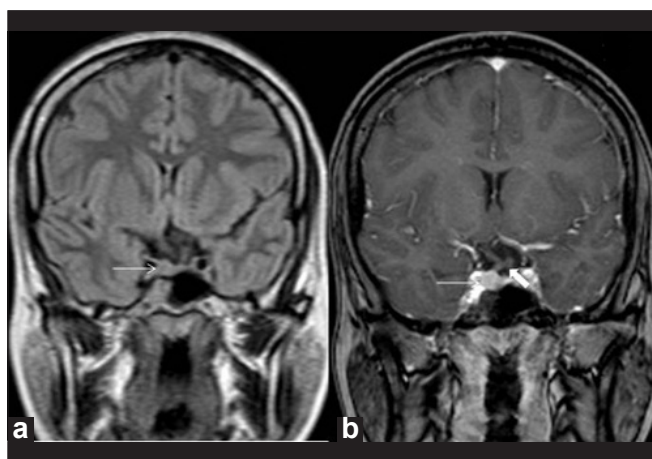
Pituitary microadenoma. Coronal fluid attenuated inversion recovery (a) and routine T1-weighted postcontrast (b) images of brain show a small nodular lesion (thin white arrow) involving the right side of the pituitary gland producing mild bulge of superior margin of the gland and leftward deviation of the pituitary stalk (thick white arrow). The lesion appears isointense to the gland on the fluid attenuated inversion recovery image and shows an enhancement pattern almost identical to the normal pituitary gland
